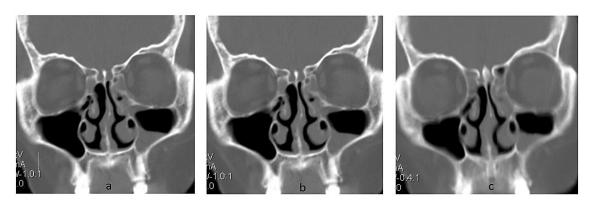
Paranasal Sinuses CT Scan Image (a). slice Thickness of 3.2mm (b) Slice Thickness of 5mm (c) Slice Thickness of 7.5mm
